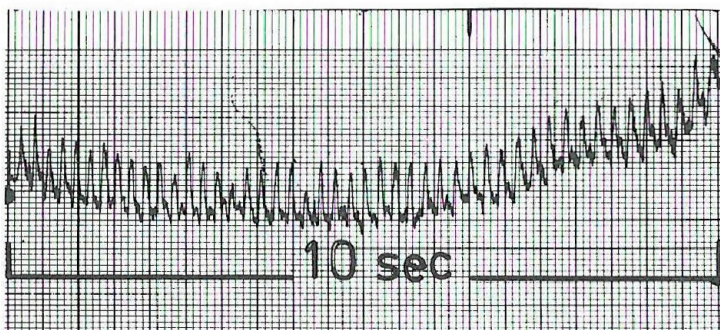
The thermo-trace pattern of the audio signal derived from the Doppler crystal and showing the heart rate.
